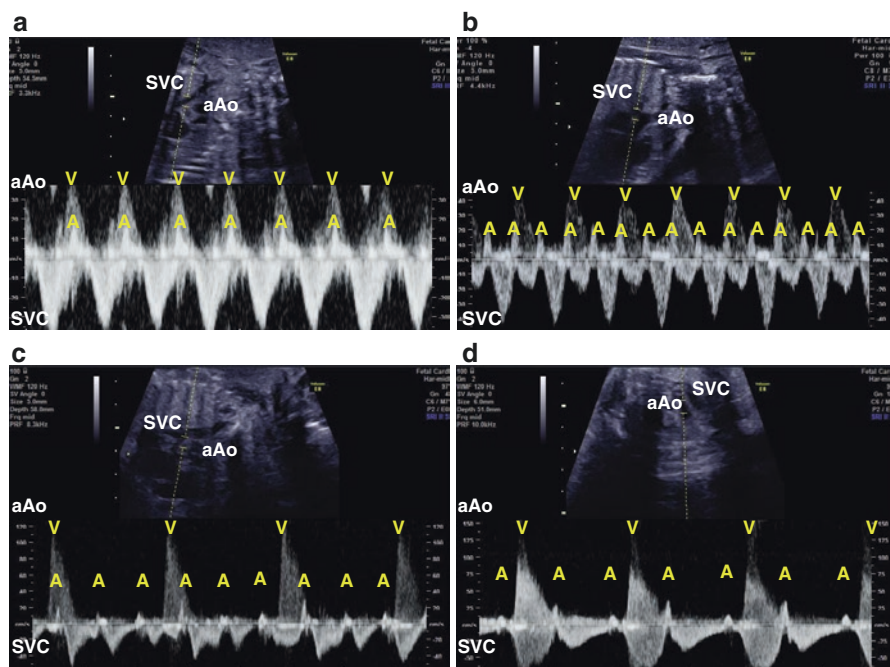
Two-dimensional imaging showing a segment of the ascending aorta (aAo) adjacent to the superior vena cava (SVC) draining into the right atrium. Pulsed Doppler echocardiography shows aortic ejection waves (V-waves) recorded above the zero velocity line. Anterograde venous flow in the SVC in the opposite direction is shown below the line, and small venous retrograde waves (A-waves) caused by right atrial contraction are above the same line. (a) Fetal tachyarrhythmia with a short ventriculoatrial pattern, suggesting atrioventricular reentrant tachycardia. (b) Fetal tachyarrhythmias with 2:1 atrioventricular conduction, suggesting atrial flutter. (c) Fetal bradyarrhythmia with a regular normal atrial rhythm and rate but with the ventricles beating independently at a much slower rate, suggesting complete atrioventricular block. (d) Fetal bradyarrhythmia with 2:1 atrioventricular conduction, suggesting congenital second-degree atrioventricular block or functional atrioventricular block due to long QT syndrome
